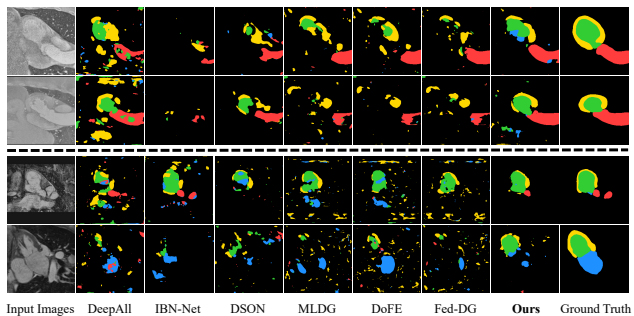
Visualization results on Cardiac segmentation task of different methods. First two rows: “MR to CT” task; Last two rows: “CT to MR” task.
